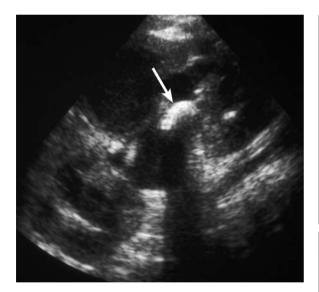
Pyonephrosis, uro-lithiasis and obstructive uropathy. Ultrasound. Sagittal scan of the left kidney. A lithiasis is visible within the dilated urinary tract (*arrow*). The urine appears echogenic
